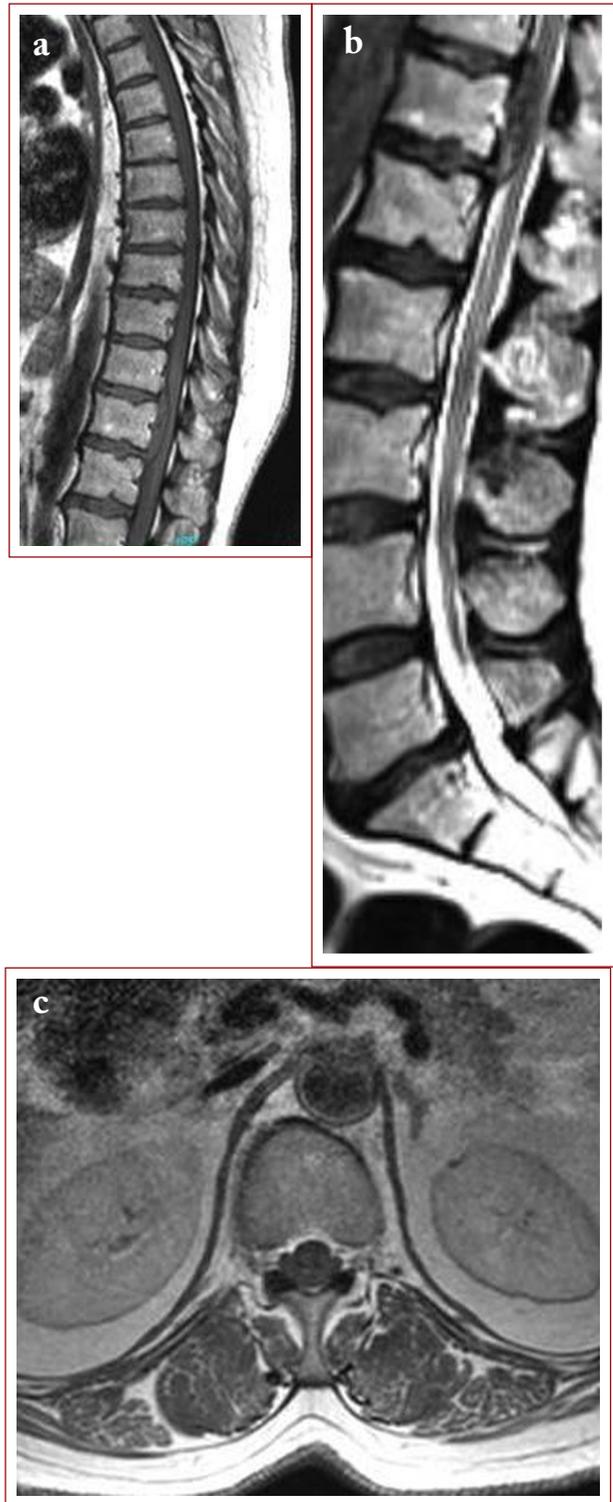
a) T1-weighted sagittal MRI section of thoracic disc hernia at T11–12 level, b) T2-weighted sagittal MRI section and c) T2-weighted axial MRI section
